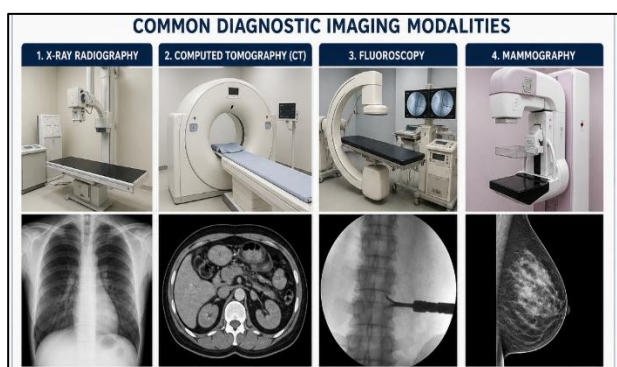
Common diagnostic imaging modalities (X-ray, CT, fluoroscopy, mammography).
